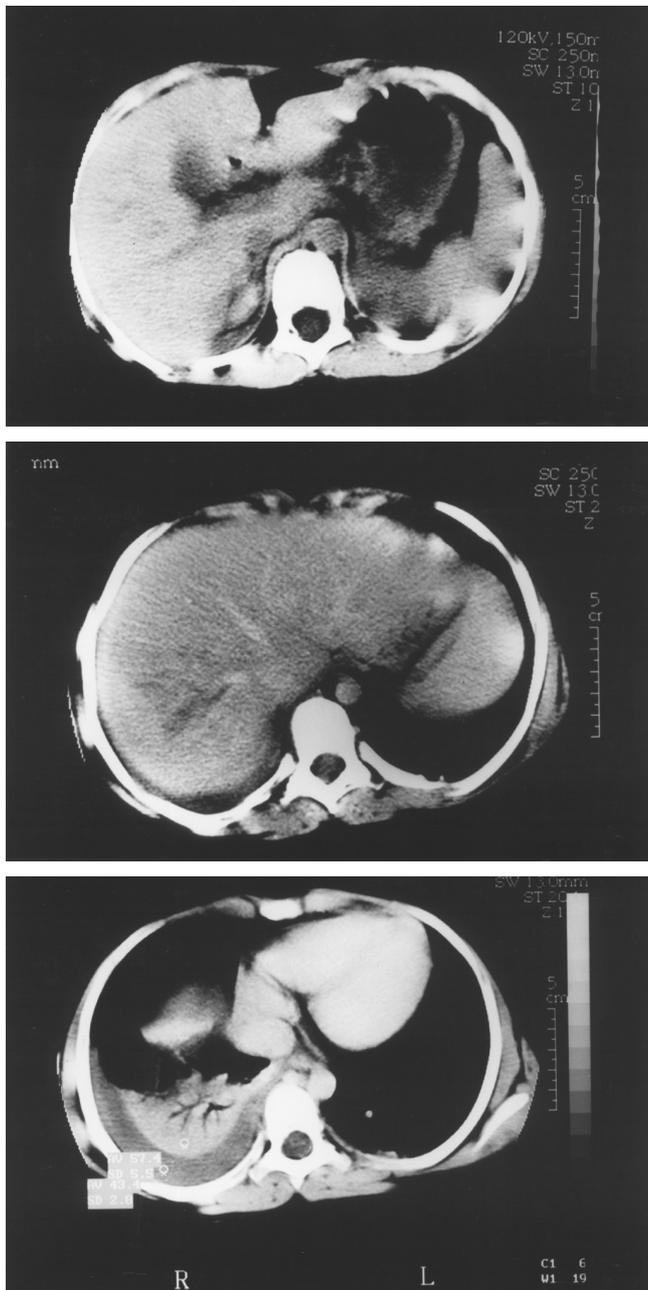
CT scans of a 9-year-old girl injured in a motor vehicle accident. [A] Non-enhanced CT scan reveals an ovoid hematoma in right adrenal. [B] Contrast-enhanced CT scan shows laceration of right lobe of liver. [C] CT scan through lower chest reveals right pleural effusion and contusion of the right lower lobe.
